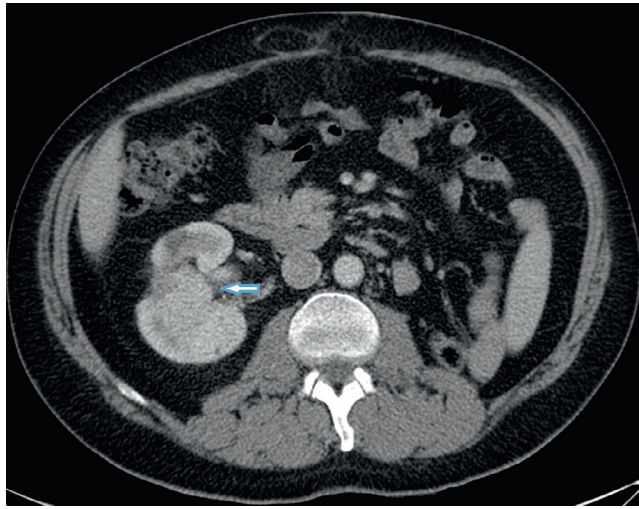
■ Local recurrence of renal cell carcinoma following cryotherapy. Dynamic post-contrast CT demonstrates a soft-tissue mass in the mid pole of the right kidney (see arrow) with overlying cortical atrophy. The patient had received previous cryotherapy to a 3-cm mass, but follow-up imaging demonstrated a progressive mass. Biopsy confirmed recurrence, and under intraoperative US guidance, a successful open partial nephrectomy was performed.
